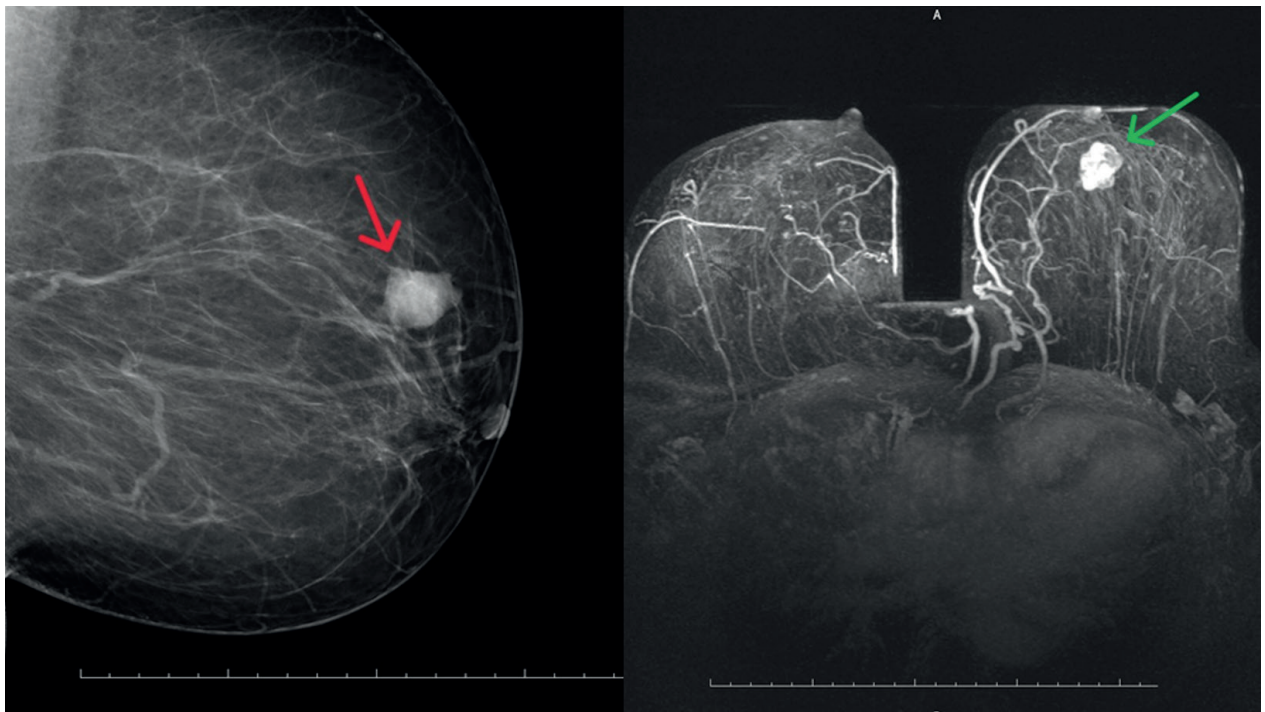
(a) Mammography showing a mass in the left retroareolar region (red arrow). (b) Dynamic contrast-enhanced breast MRI showing an irregular enhancing lesion in the left breast (green arrow).
